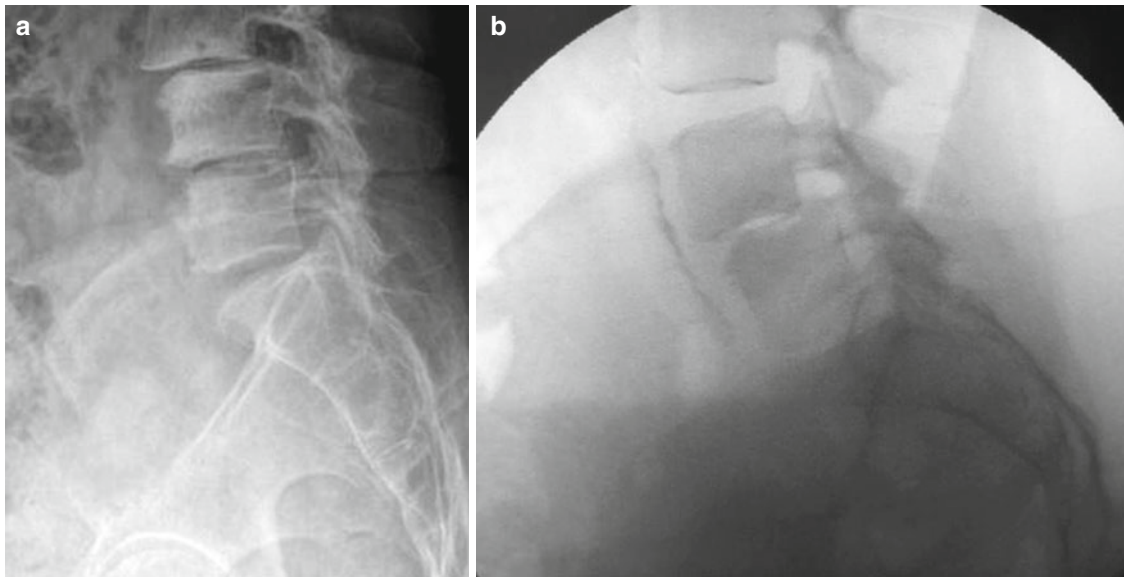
Lateral radiography showing standard iliac crest position (a) and a high iliac crest (b) in patients with L4–5 disease (Images used with permission from William D. Smith, MD)
